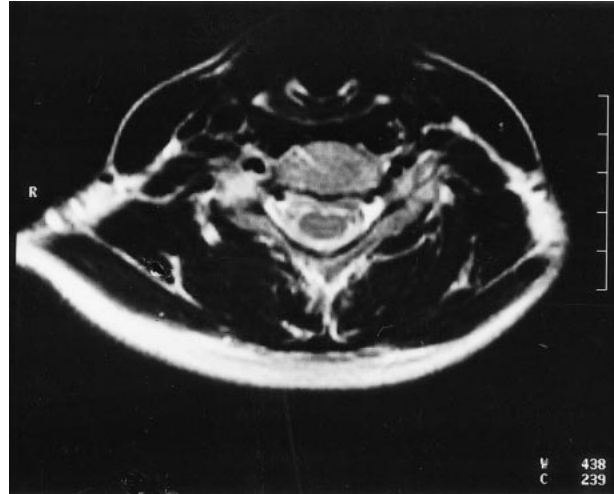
Axial T2-weighted turbo spin-echo sequence (3900/120) at C7–T1 level showing increased signal in the paraspinal soft tissues close to the right exiting root. This finding was interpreted as cerebrospinal fluid leakage.
